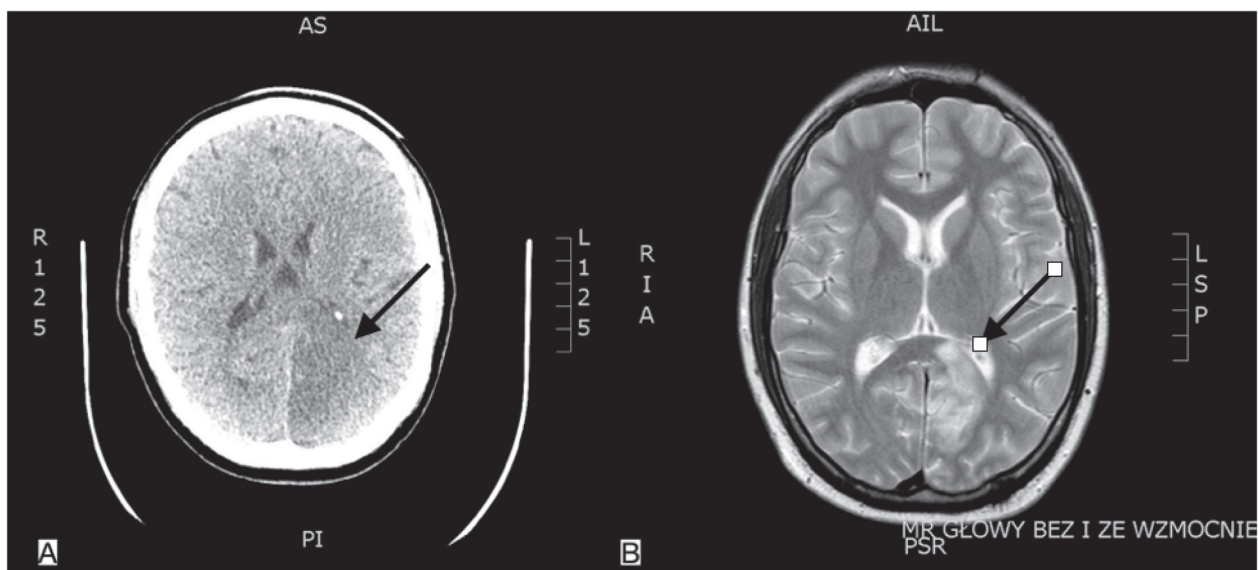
Non-contrast head MRI: hypodense area with characteristic fresh ischemic change – stroke focus visible in brain's left hemisphere (in parietal and occipital lobes); B. Head MRI with contrast
